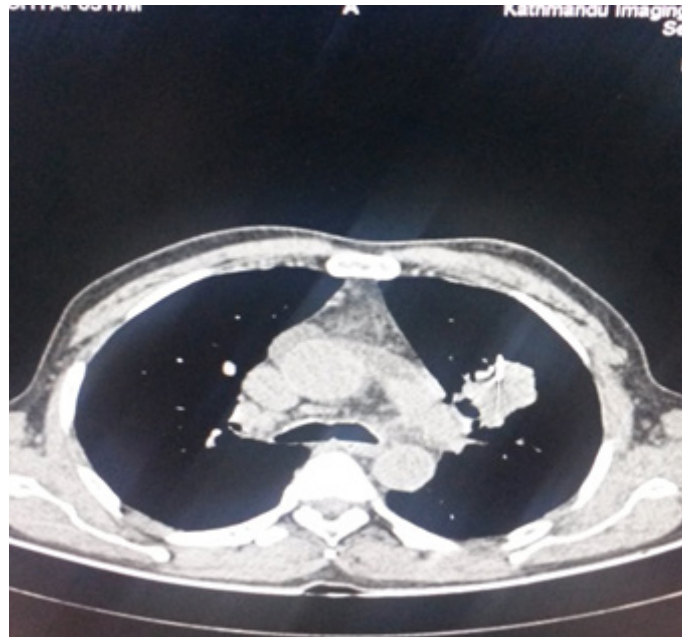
CT shows mass with needle insitu showing CT guided FNAC
